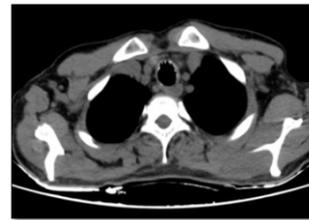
Axial CT Chest image (plain scan) showing anterior tracheal wall irregularity and calcifications.
